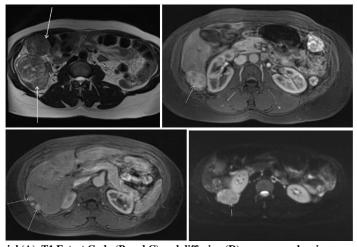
Abdominal MRI in T2 Axial (A), T1 Fatsat Gado (B and C) and diffusion (D) sequences, showing myomatous, cellular, hyper diffusion signal formations, intensely enhanced after injection of contrast medium in favour of cellular, intra-peritoneal myomas, essentially lateralized in the peri-hepatic subscapular area and in the right paracolic gutter.
